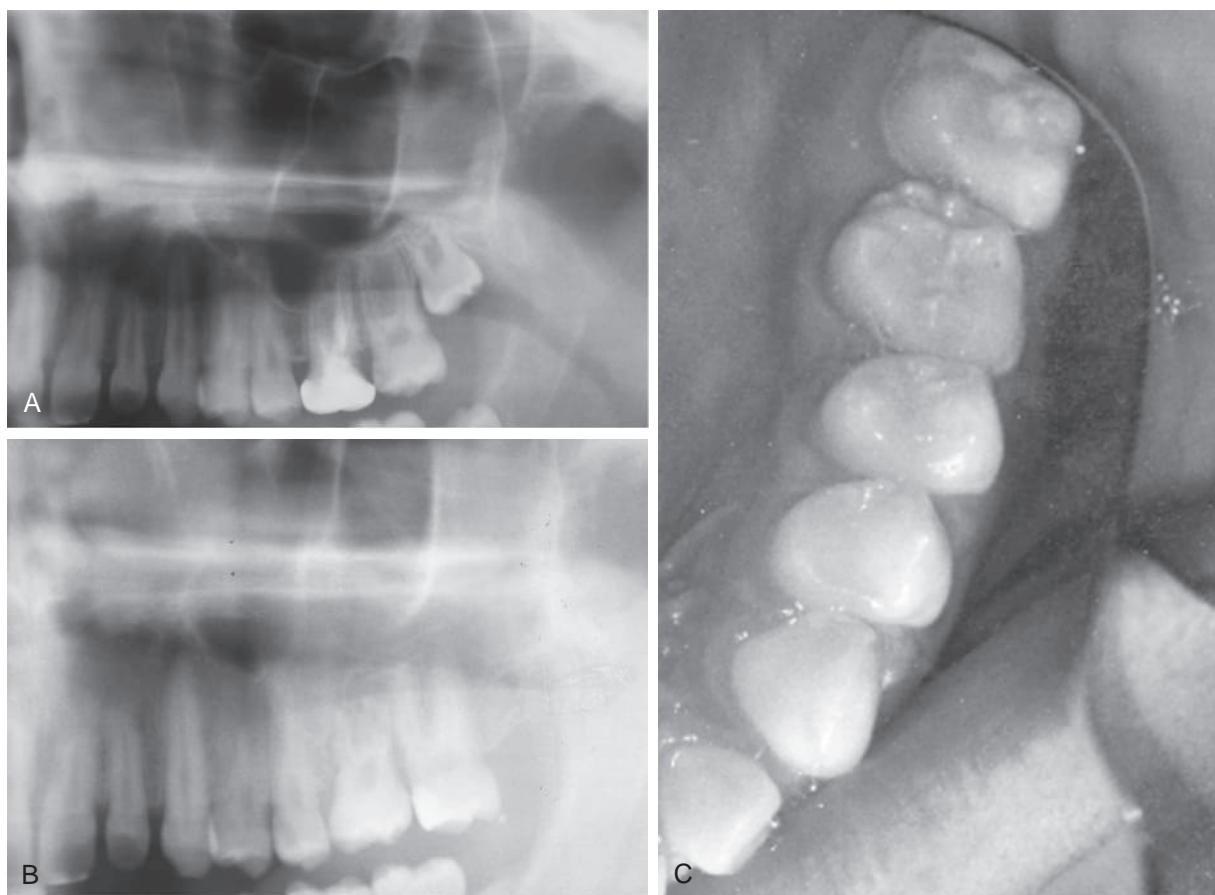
Third molar autotransplantation. (A) Radiograph showing failed attempt at maintaining first permanent molar and minimal root development of third permanent molar. (B) Radiographic and (C) clinical views of third molar 15 months after autotransplantation. Note the continued root development.
